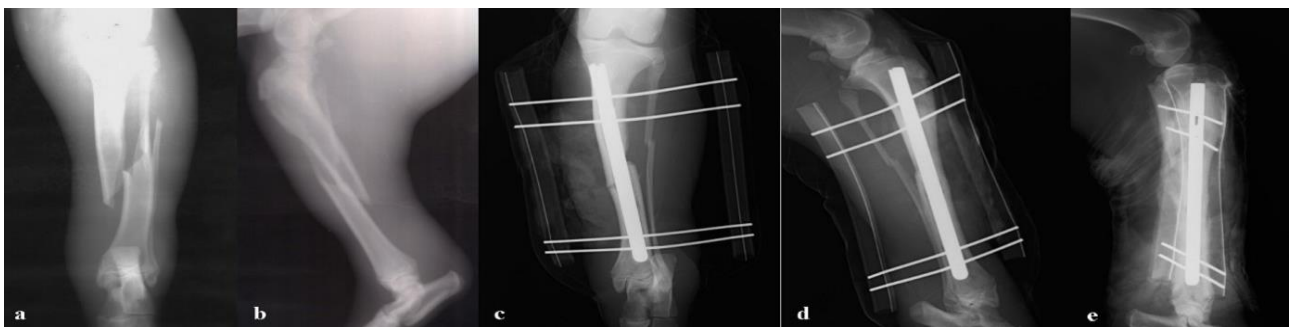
Preoperative and postoperative radiographs of case no 4. a and b. preoperative, c. and d. postoperative 10th day, e. postoperative 45th day radiographs of case 4.
